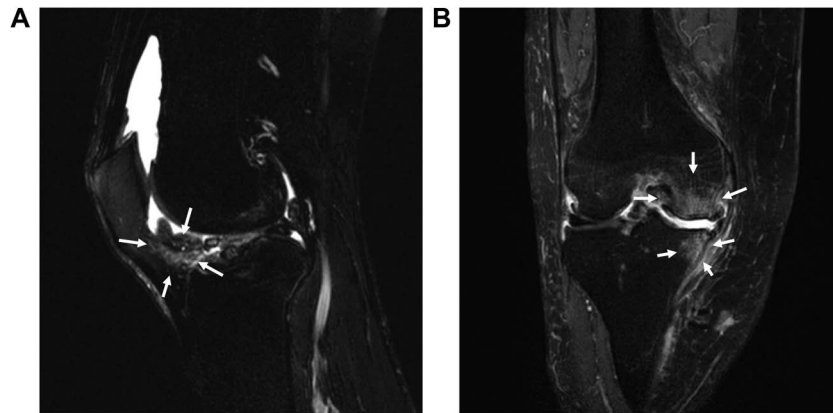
Examples of magnetic resonance imaging findings. (A) Hoffa synovitis and (B) bone marrow lesions.
